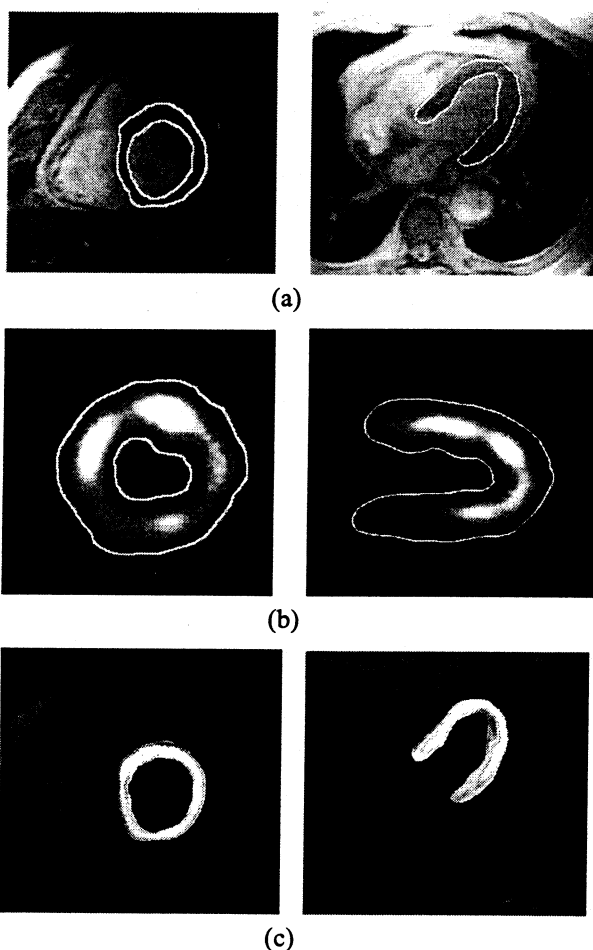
results relevant to a normal subject; left side: short axis view; right side: long axis view; (a): MRI (b): SPECT; (c): resulting fused images.
